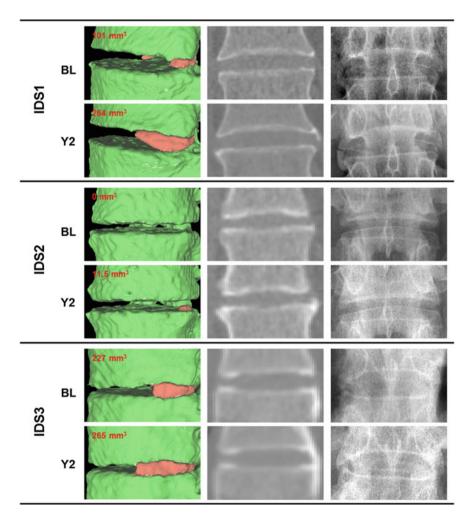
Examples of syndesmophyte progression from baseline (BL) to year 2 (Y2). From *left* to *right* 3D surface mesh (syndesmophytes in *red* and vertebral bodies in *green*), CT slice, radiograph
